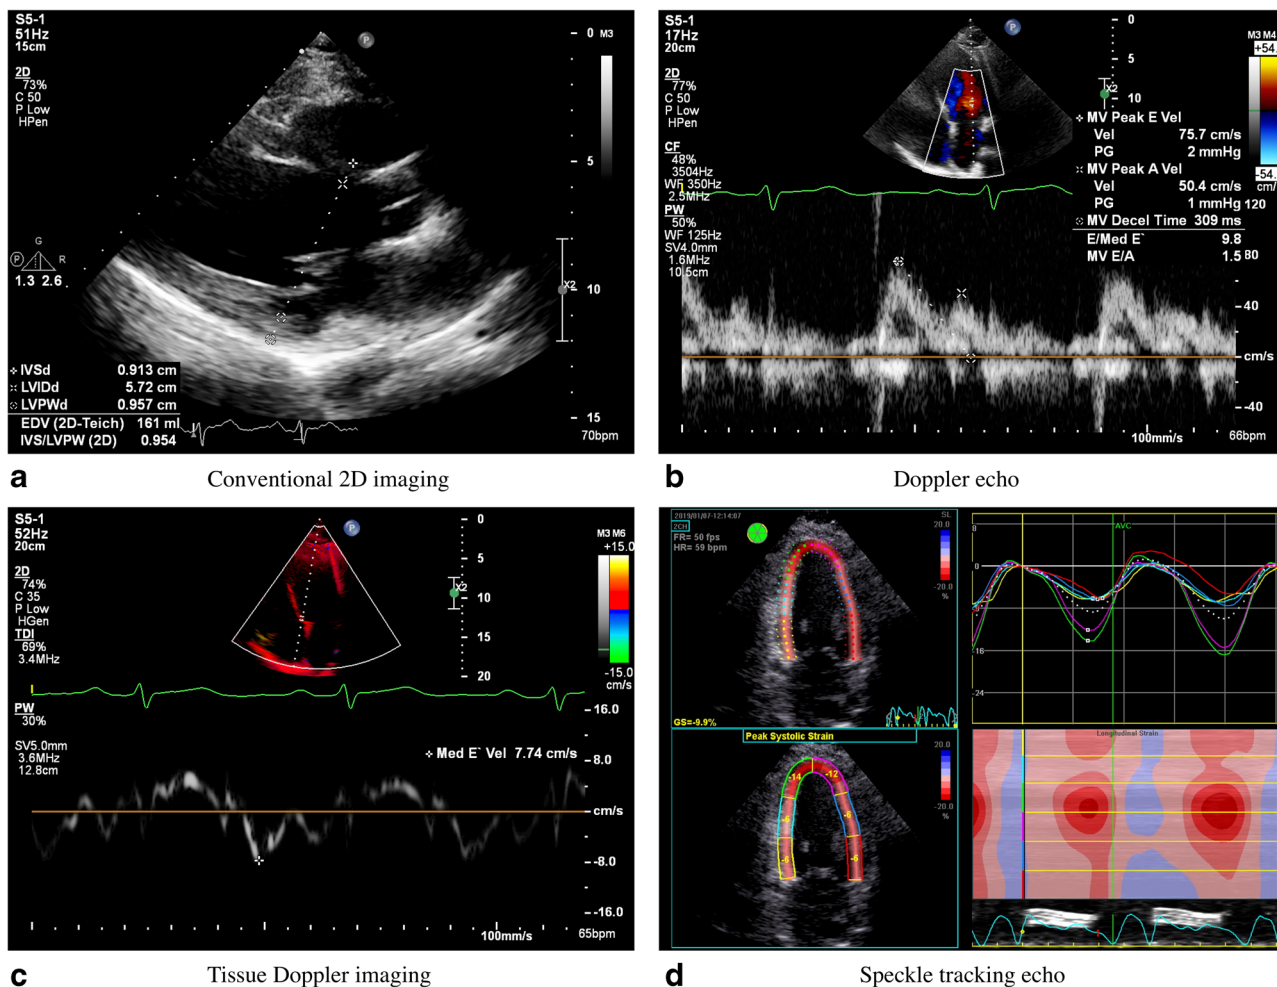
Examples of echo imaging modalities. a Conventional 2D imaging. b Doppler echo. c Tissue Doppler imaging. d Speckle tracking echo.
